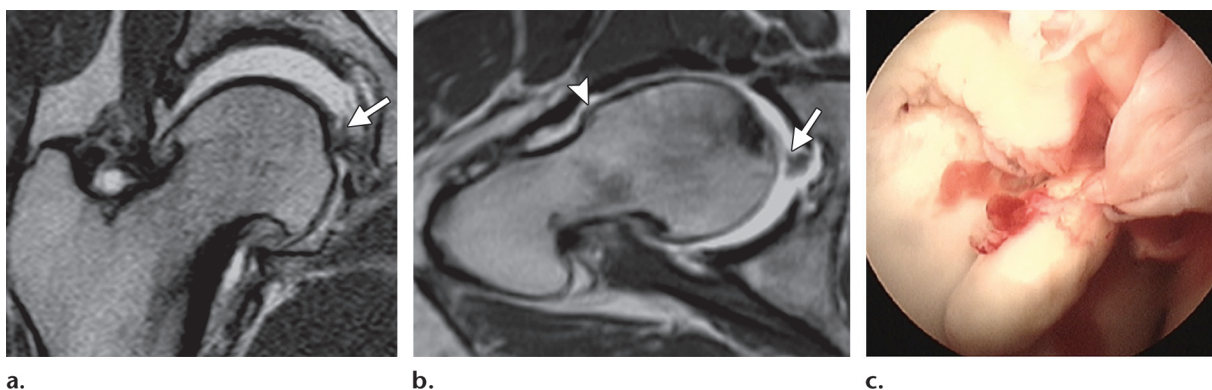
Complete tear of the ligamentum teres. (a, b) Coronal (a) and axial oblique (b) T1-weighted MR arthrograms obtained with the leg in traction show a chronic, complete tear of the ligamentum teres at its foveal attachment (arrow) and severe secondary instability, recognizable by a marked increase in joint space when the leg is in traction. Cam-type femoroacetabular impingement also is seen, with an abnormal protuberance at the femoral head-neck junction (arrowhead in b). (c) Arthroscopic image shows a tear in the ligamentum teres at the foveal attachment.
